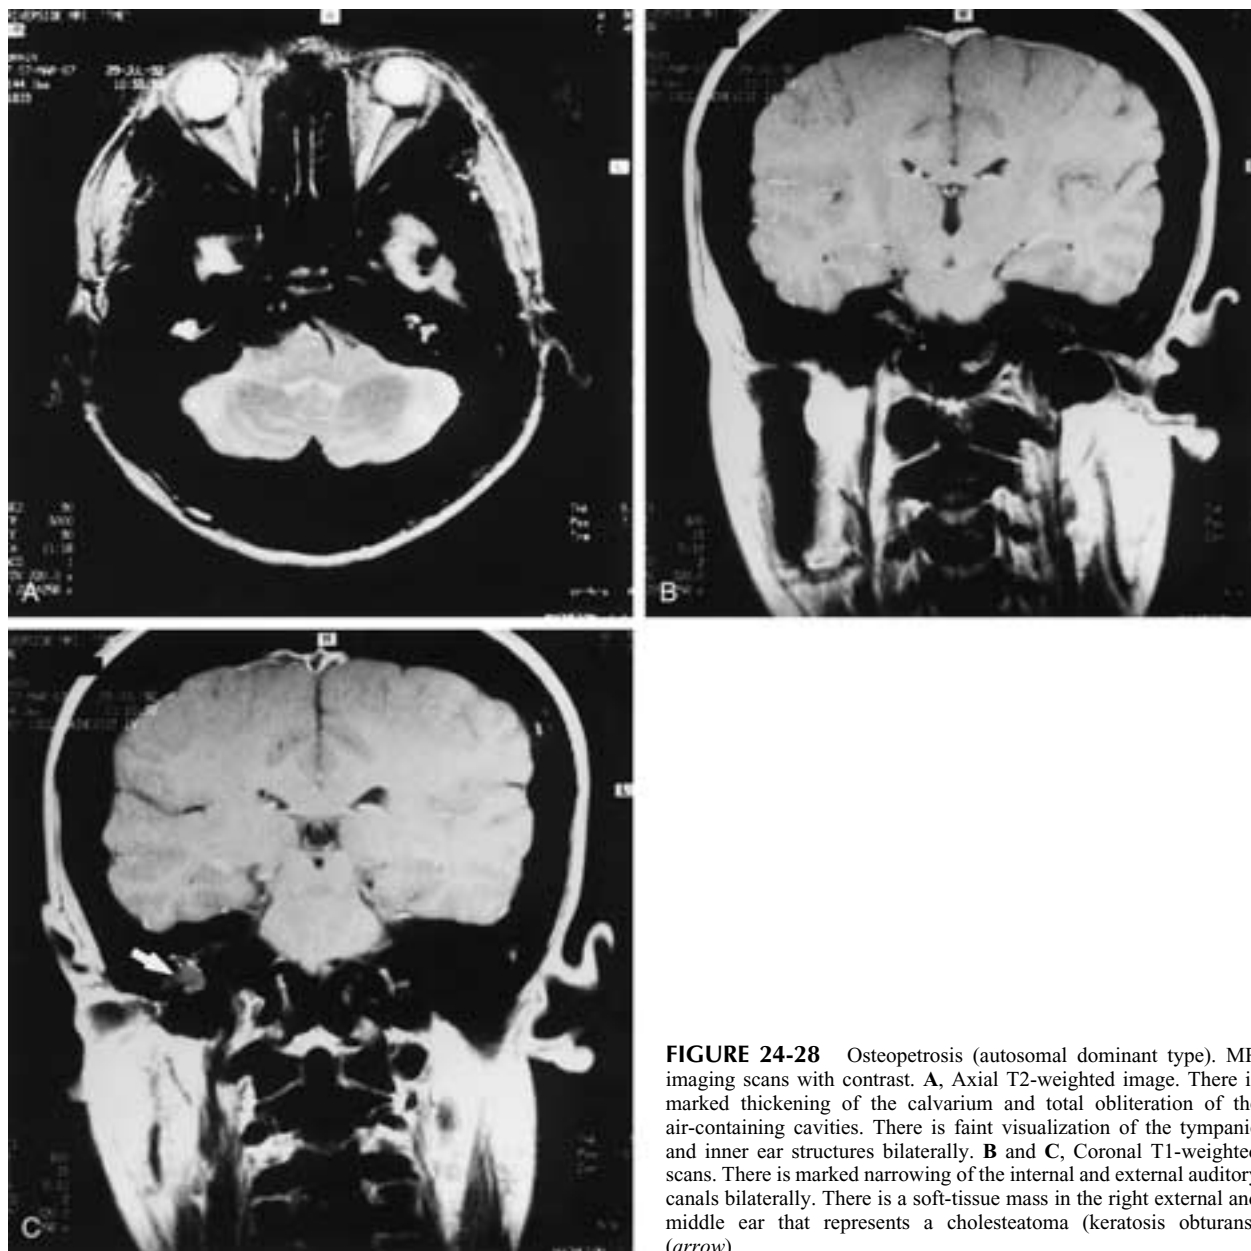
Osteopetrosis (autosomal dominant type). MR imaging scans with contrast. A, Axial T2-weighted image. There is marked thickening of the calvarium and total obliteration of the air-containing cavities. There is faint visualization of the tympanic and inner ear structures bilaterally. B and C, Coronal T1-weighted scans. There is marked narrowing of the internal and external auditory canals bilaterally. There is a soft-tissue mass in the right external and middle ear that represents a cholesteatoma (keratosis obturans) (arrow).
